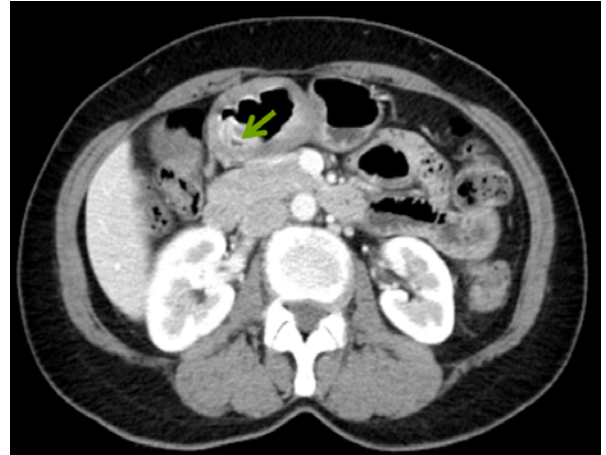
Computed tomography with contrast reveals a heterogeneously enhanced mass 5cm in size at antrum (green arrow).
